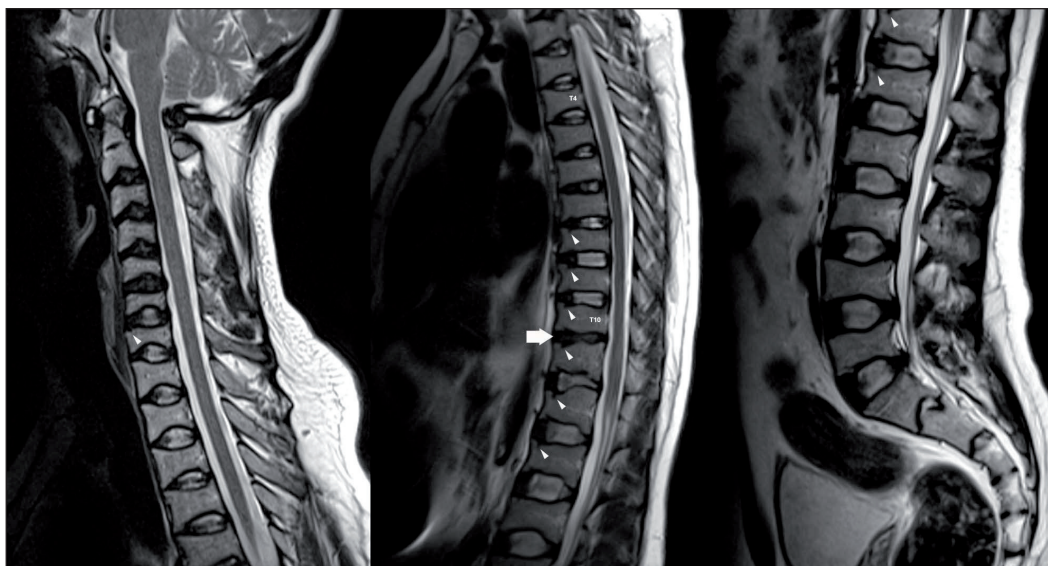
T2-weighted magnetic resonance images of cervico-thoraco-lumbar spine showing Schmorl nodes in the cervical spine at the C7 level and in the thoracic spine from T8 to L1 (arrowhead). Narrowed disc space at T10-T11 (arrow)
